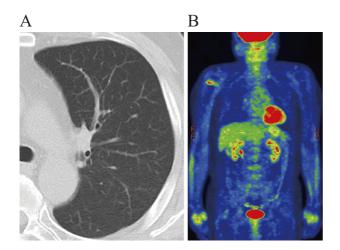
Chest CT (A) and ¹⁸F-FDG PET-CT (B) scans after the completion of eight courses of R-CHOP. Diffuse multiple small nodules and the diffuse FDG uptake disappeared completely in the lung fields on CT and FDG-PET/CT findings, respectively. FDG: fluorodeoxyglucose, PET: positron emission tomography
